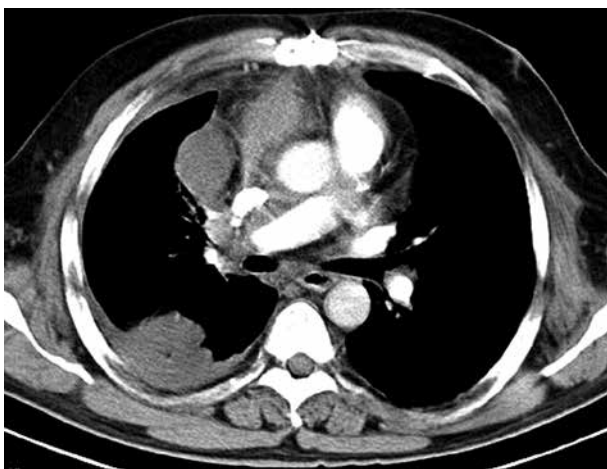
Thoracic computerized tomography (CT) shows mass in the right atrium expanding in the right hemithorax with fluidothorax
